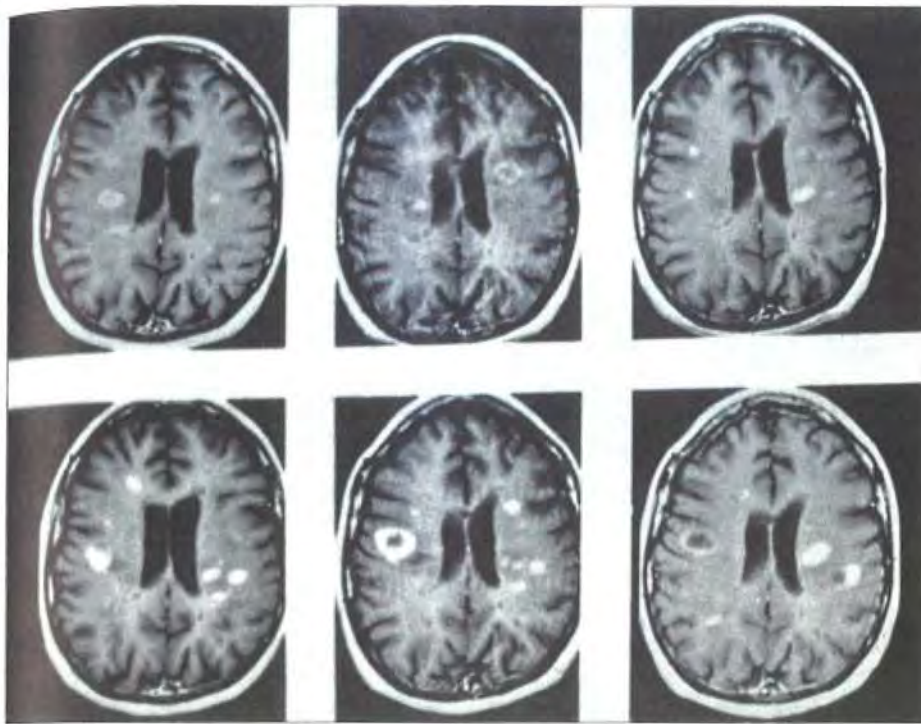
Serial monthly gadolinium enhanced T_1 -weighted brain MRI over 6 months (starting at the top left and ending at the bottom right) in a patient with relapsing–remitting multiple sclerosis. Several new enhancing lesions appear each month and cease enhancing 1 or 2 months later. Some lesions show homogeneous enhancement while others display ring enhancement.
